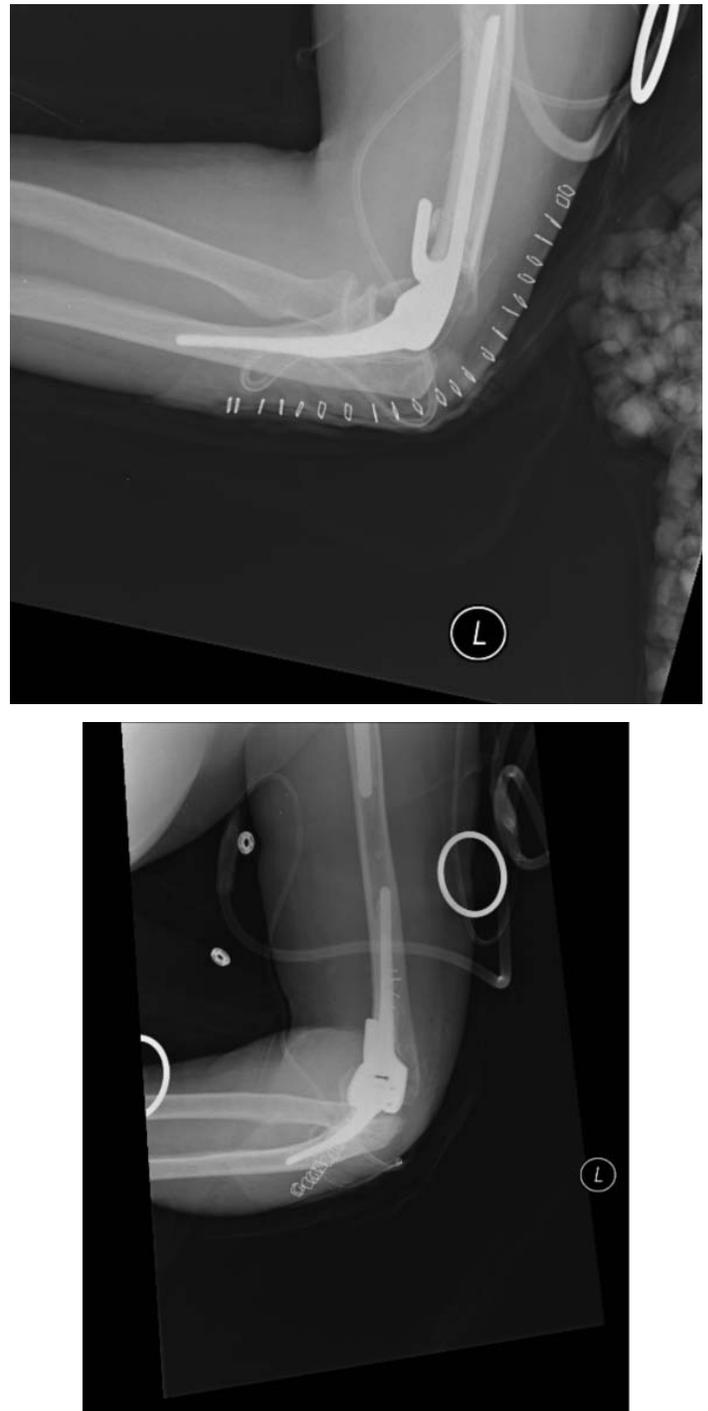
Postoperative elbow AP and lateral radiographs.
